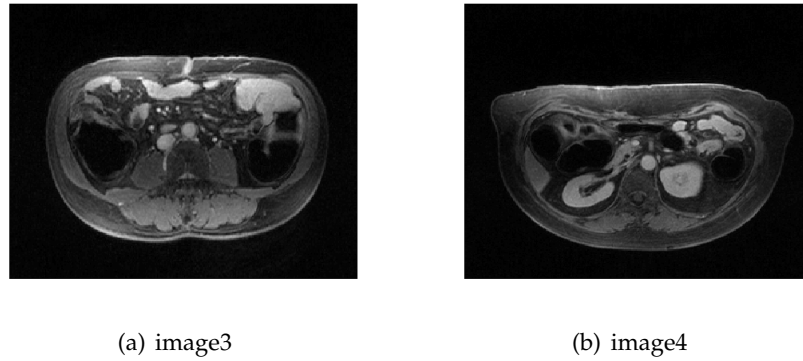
MR images from two other datasets
